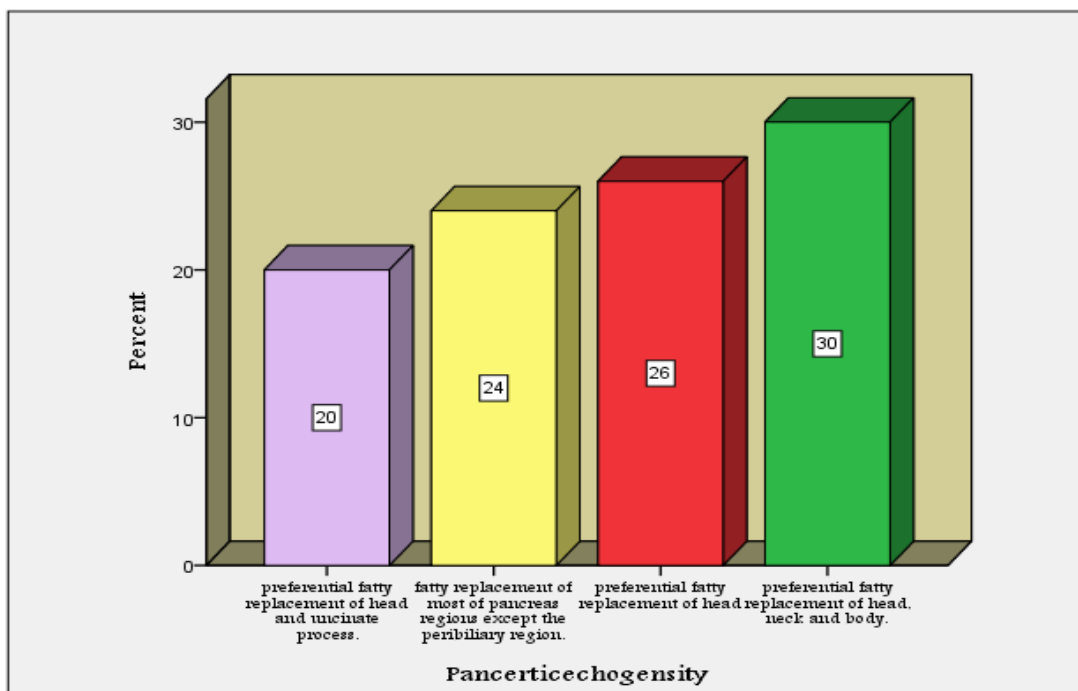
Sonographic Finding /Pancreatic echogenicity Distribution
